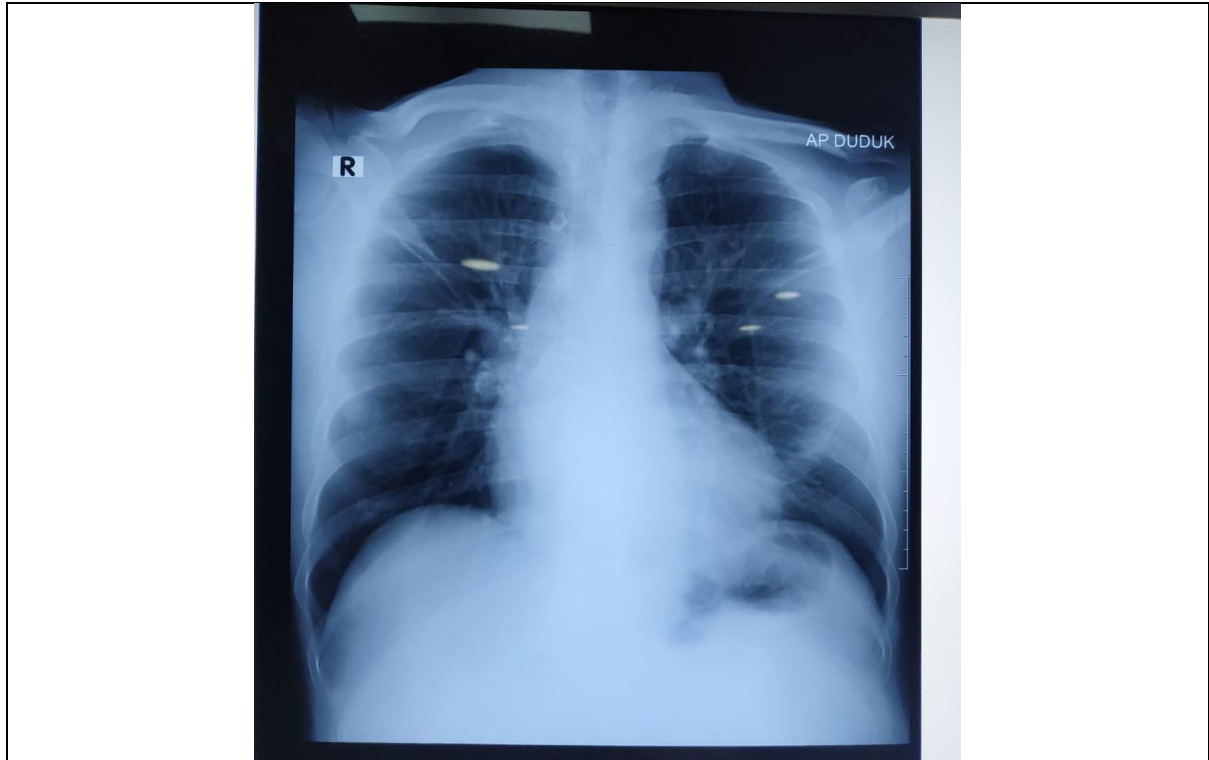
Normal chest X-Ray
